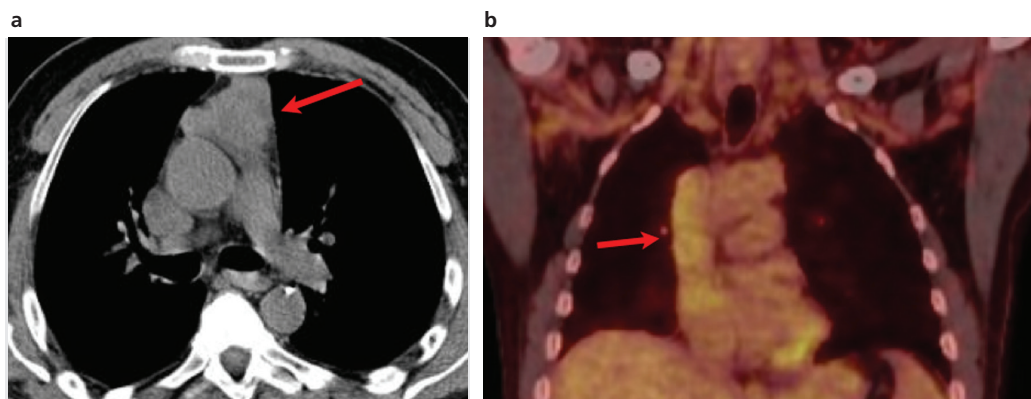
Invasive thymoma. Axial images. Fifty-two year-old man. Non-contrast-enhanced CT (A) shows a prevascular mass with loss of fat plane. Coronal PET-CT fusion imaging (B) shows a hypermetabolic mass (SUV_{max} 4.5) extending through the superior vena cava into the right atrium.
